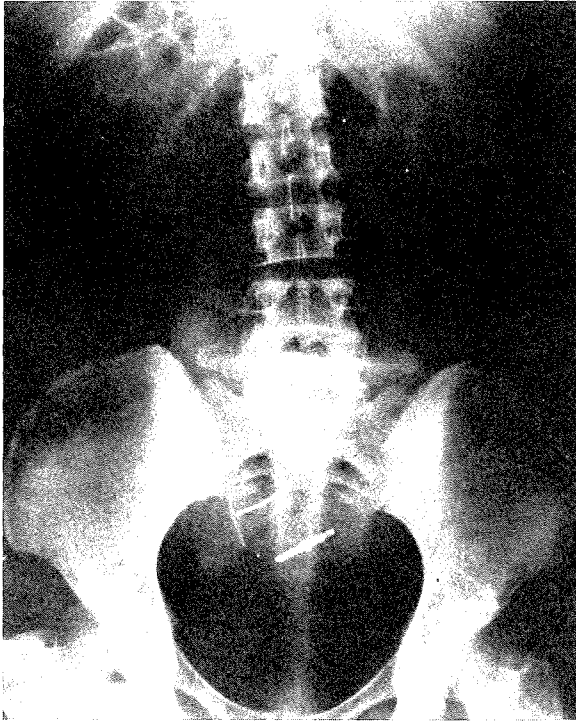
X-ray abdomen - The newly inserted Lippes loop is in utero; the Copper T device is outside the uterus.
